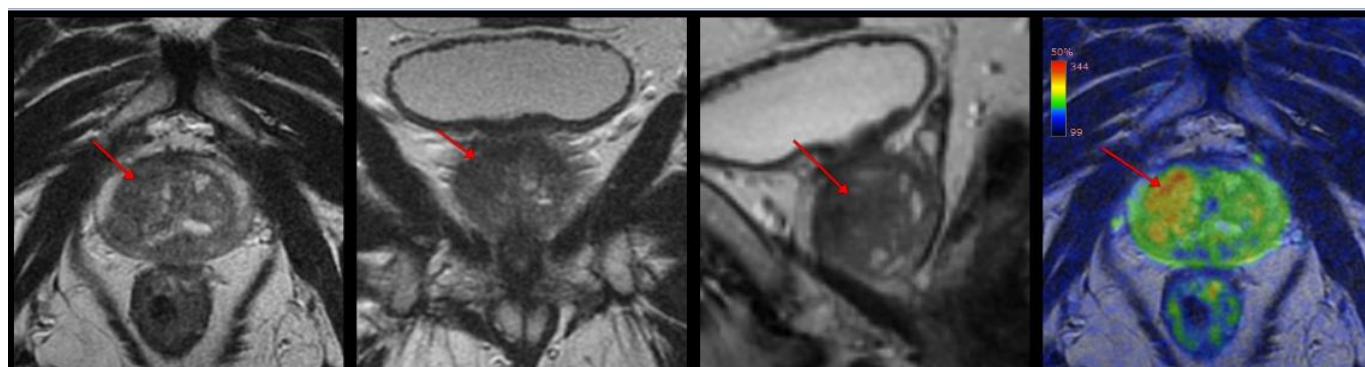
MRI of the tranzitional zone PCa
